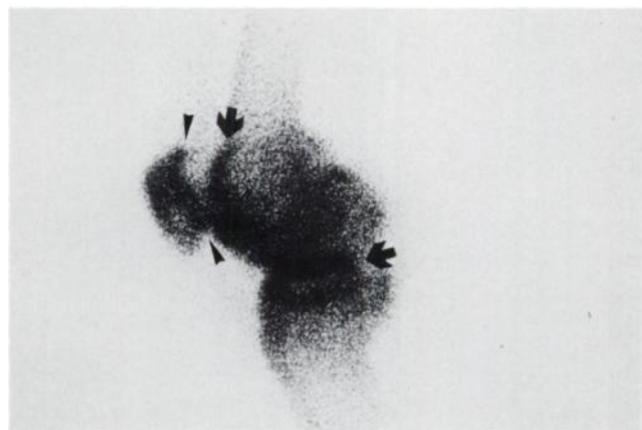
Medial pinhole scintigraph of the osteoarthritic right knee and patella of Patient 11 shows diffuse tracer uptake in the whole retropatellar facet (arrowheads) and curvilinear and linear bands of intense tracer uptake in the main osteoarthritic alterations of patellofemoral (vertical arrow) and femorotibial (horizontal arrow) compartments, respectively.
